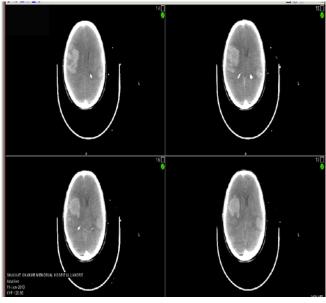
Computed tomography (CT) scan of patient, who developed accelerated hypertension, complicated by fatal intracranial bi-hemispheric bleed. Showing mass effects that progressed to trans-tentorial and impending subfalcine herniation.
